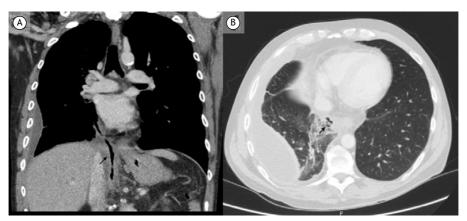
Coronal (in A) and axial (in B) CT images showing a fistulous tract (black arrows) with fluid and gas extending from the pancreatic head into the right pleural space and transposing the right hemidiaphragm.
